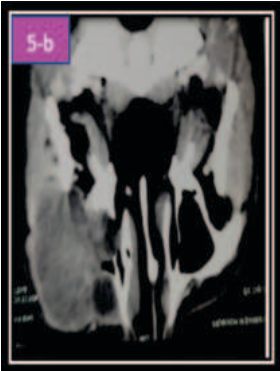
CT Shows Mixed Radiolucent-radioopaque Lesion with Erosion of Maxilla, all Walls of Maxillary Sinus
